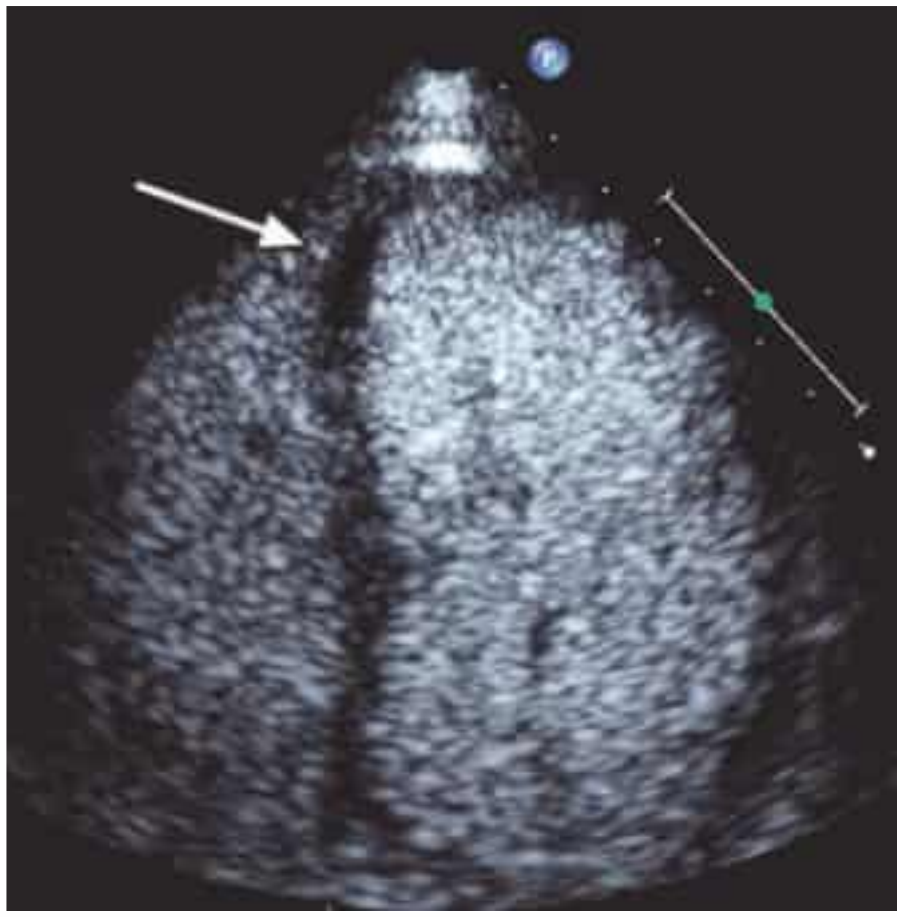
Real-time perfusion contrast echocardiography. Absent or delayed myocardial enhancement after contrast administration signifies a perfusion deficit. This image shows a localized perfusion deficit (arrow) in the apical septal region of a patient with a prior distal LAD occlusion due to single-vessel coronary disease.
